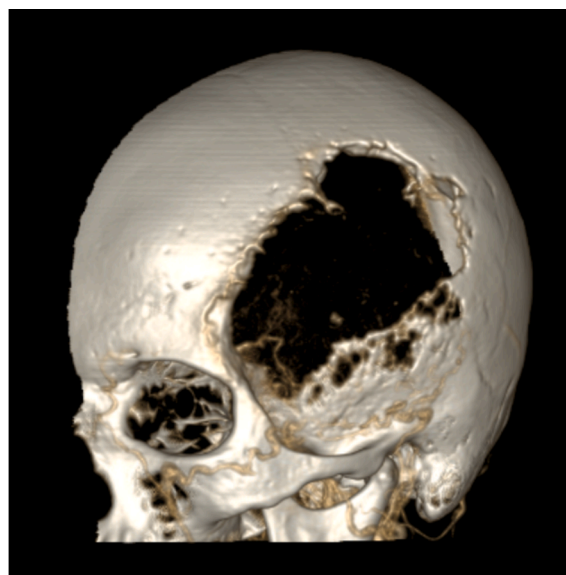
Three-dimensional CT reconstruction. Left-sided frontal, temporal, and parietal bone destruction.
